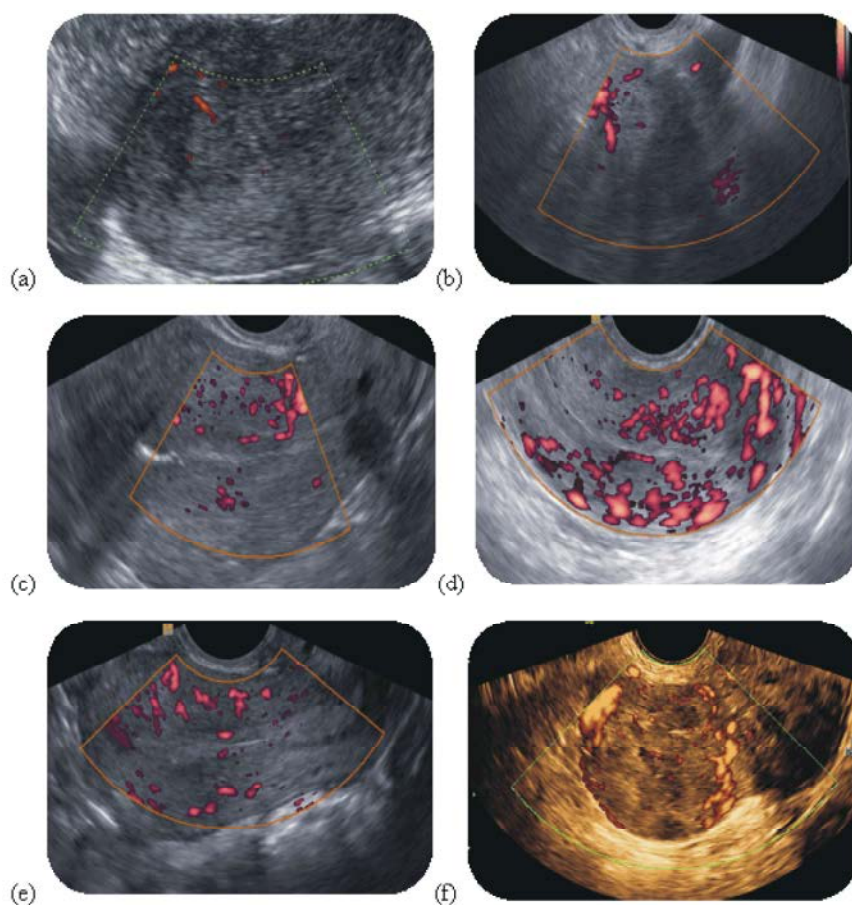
Power Doppler sonography vascular patterns according to IETA group: (a) Single dominant vessel without branching (endometrial polyp) (b) Branching single dominant vessel (endometrial polyp) (c) Multiple vessels with focal origin (endometrial atrophy) (d) Multiple vessels with multifocal origin at myometrial-endometrial junction (endometrial atrophy) (e) Scattered pattern (endometrial hyperplasia) (f) Circular pattern (submucous to interstitial myoma)
